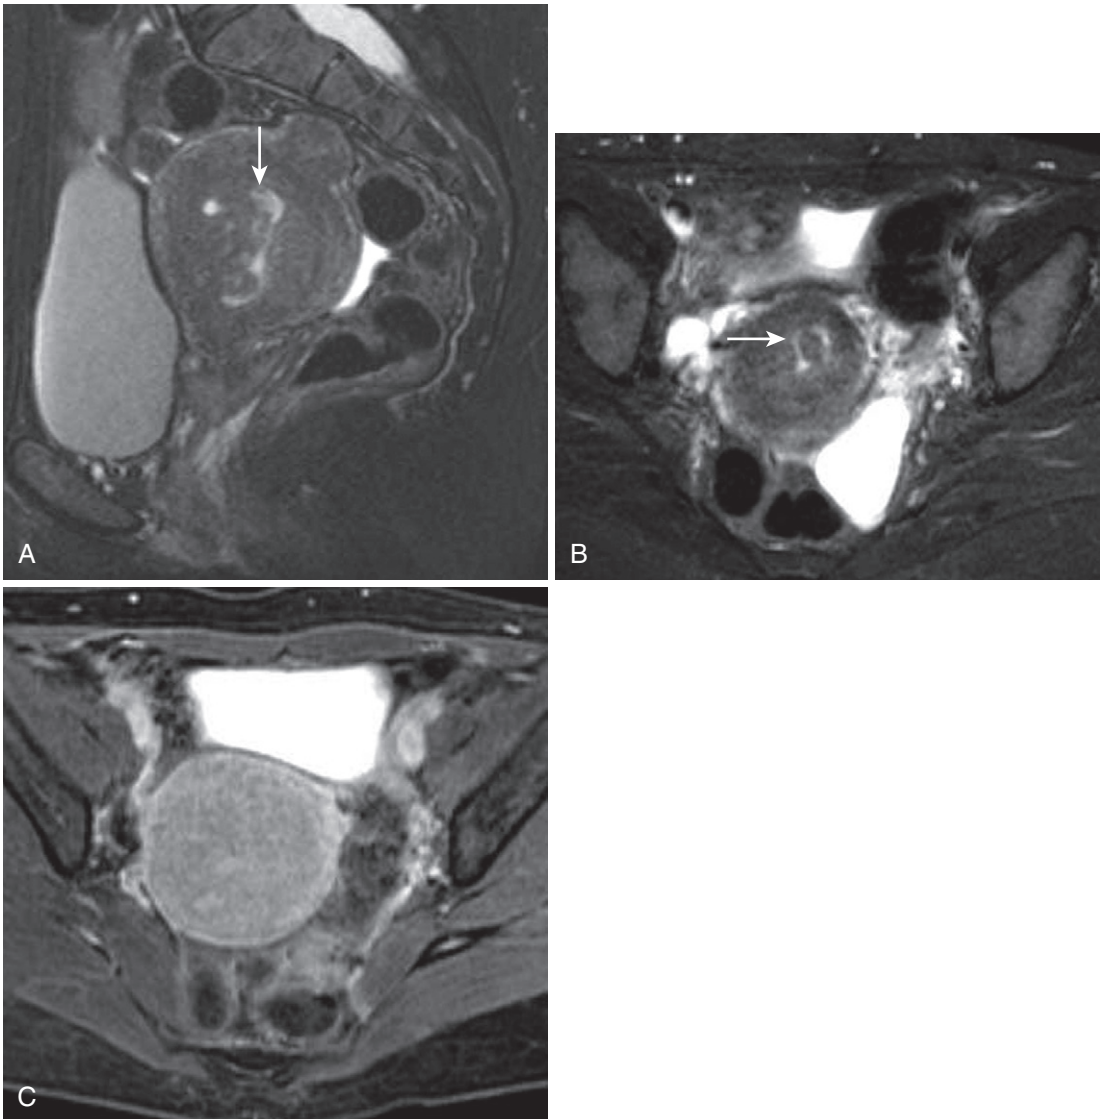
Endometrial polyp. Sagittal (A) and axial (B) T2-weighted images reveal a tubular isointense structure with cystic foci within the endometrial canal (*arrow*). C, On the axial T1-weighted fat saturated postgadolinium image, the lesion is not clearly discriminated from the adjacent myometrium, indicating moderate enhancement.
